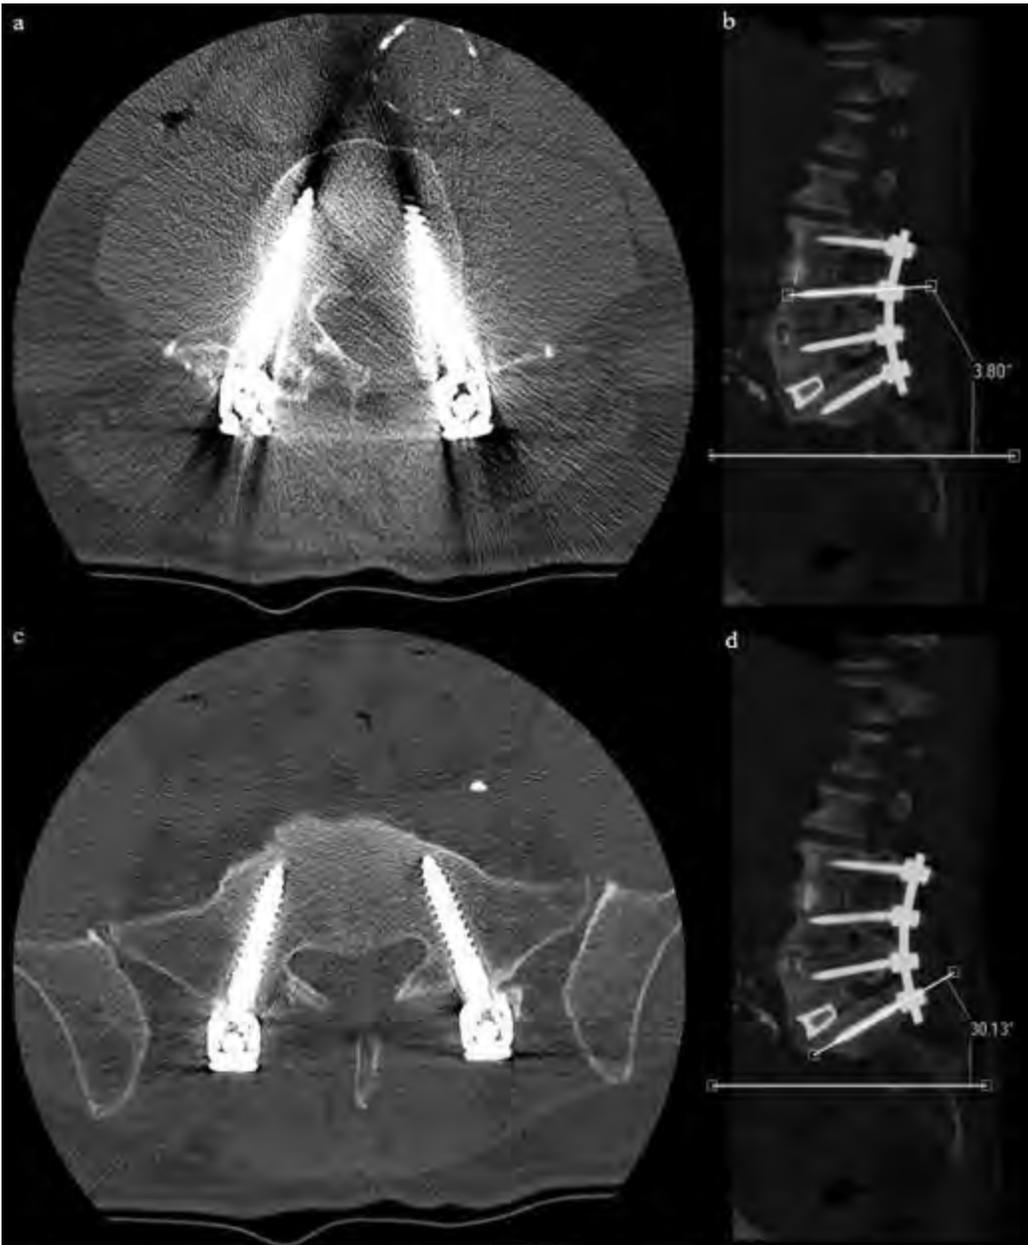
Lumbar CT of 58 year old male patient with posterior spinal instrumented fusion at L3-S1 level
